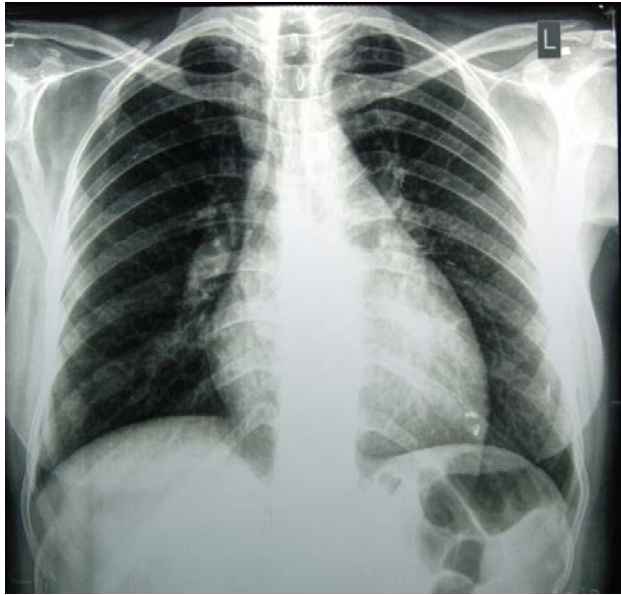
Chest radiograph showing cardiomegaly, prominent central pulmonary vessels with bilateral clear lung fields.
